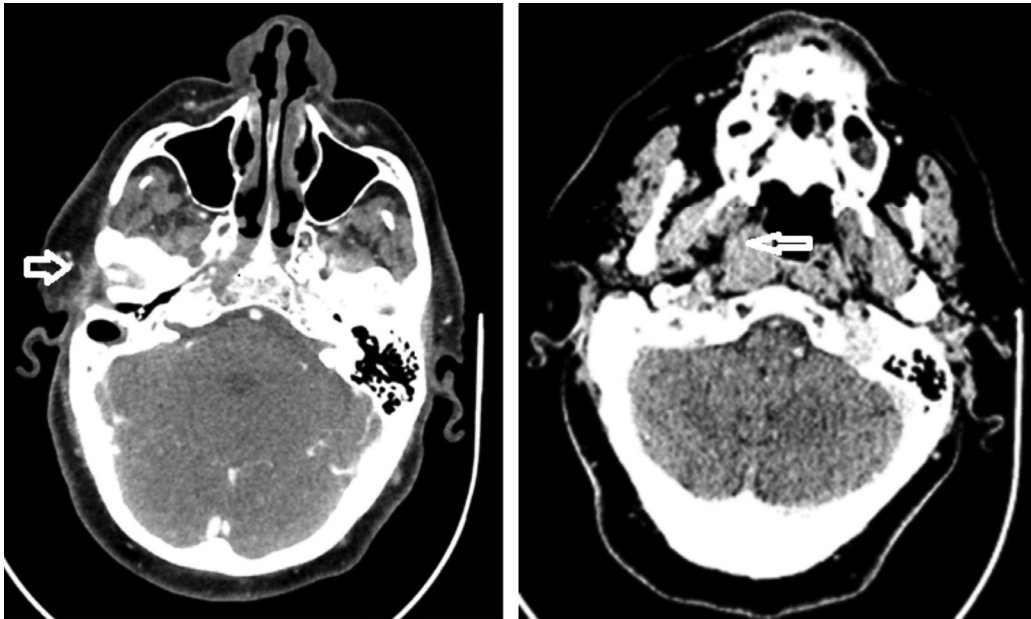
CT mastoids (left) showing previous right mastoidectomy cavity, with some soft tissue opacity (white arrow), which prompted a DWI MRI scan to assess any recurrent cholesteatoma. CT post-nasal space (right) shows some asymmetry in the nasopharyngeal tissues, more prominent on the right (white arrow).
